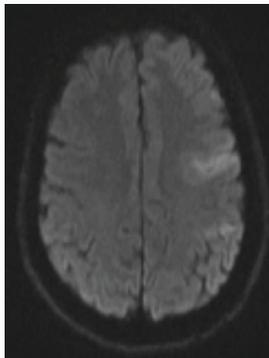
Diffusion MRI of the patient showing acute ischemia.
